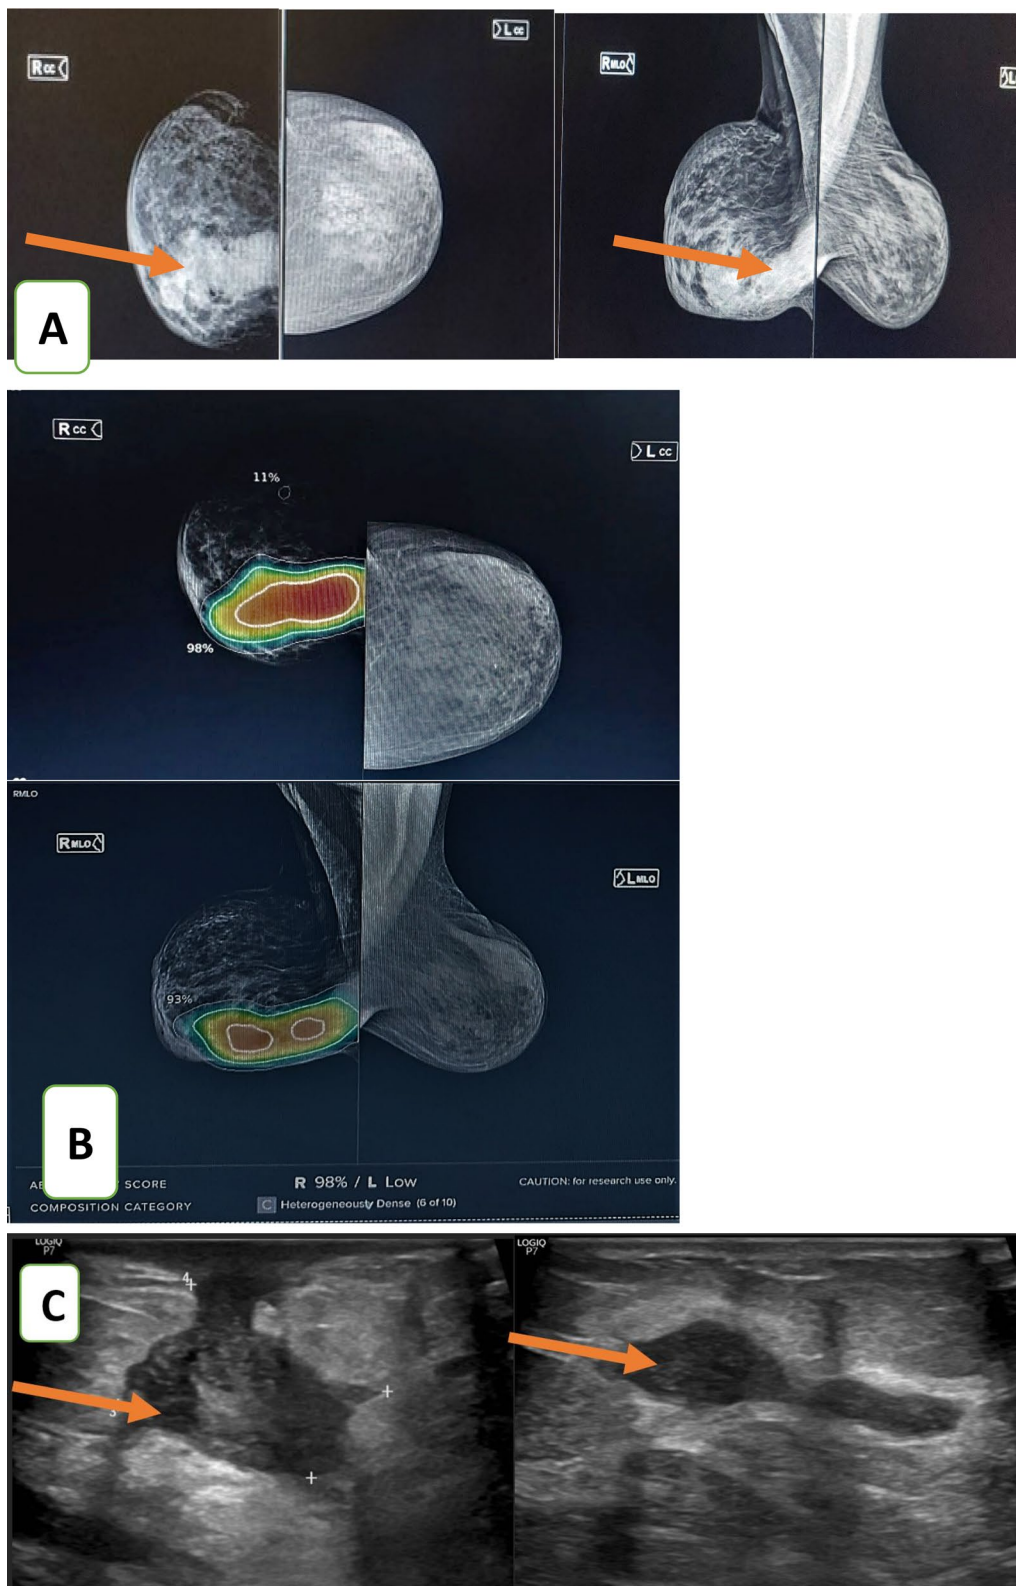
A 62-year-old female came with a tender right breast lump. A Mammography revealed a right large dense lesion with an ill-defined outline, with coarsened trabeculations and skin thickenings (BIRADS 5) B The AI highlighted an area of the right breast lesion with a 98% risk of malignancy. The color hue map showed predominantly red and yellow colors. C Ultrasound images showed irregular hypoechoic masses with tubular extensions. Pathology proved to be granulomatous mastitis. (FP by both mammography and AI)
